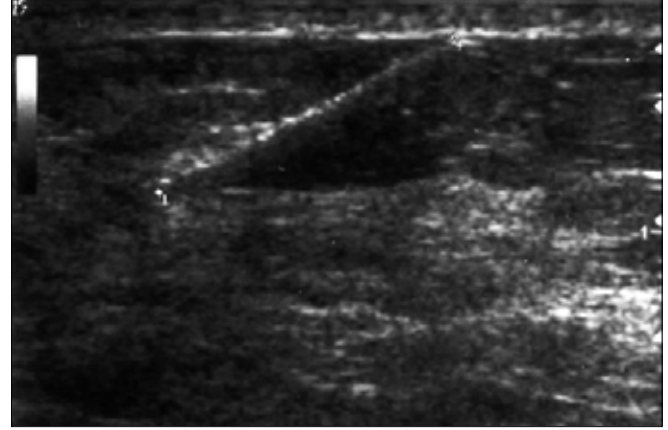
Grey-scale sonography examination showing thin linear echogenic appearance with posterior acoustic shadowing.
